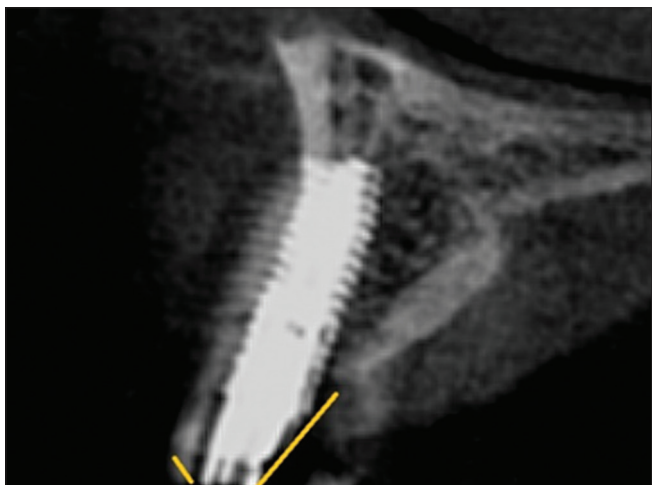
Vertical dimension (VD), CBCT radiographic presentation
